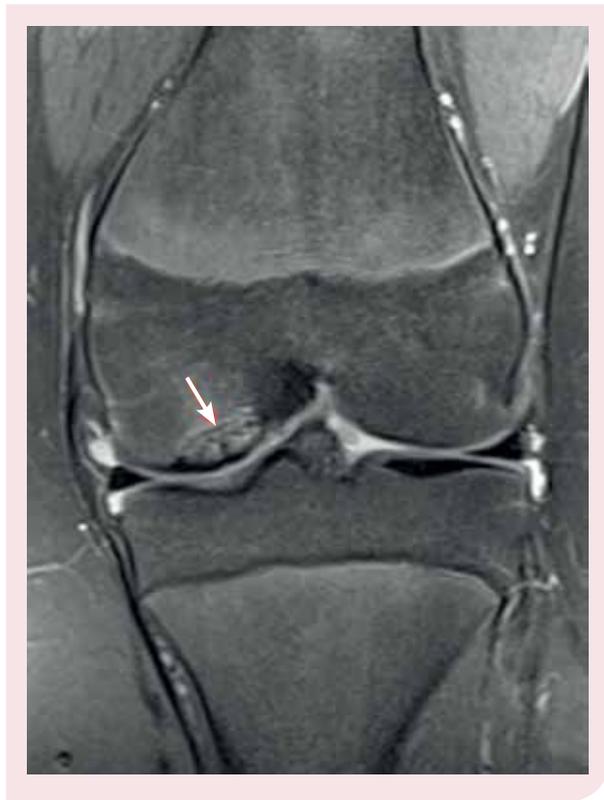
Resolution of osteochondral defect on MRI imaging.
